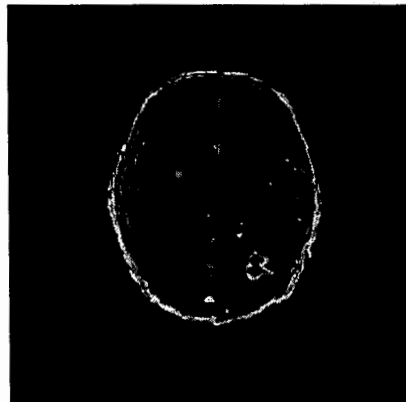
Fusion of PET and MR images of Brain by GEM
